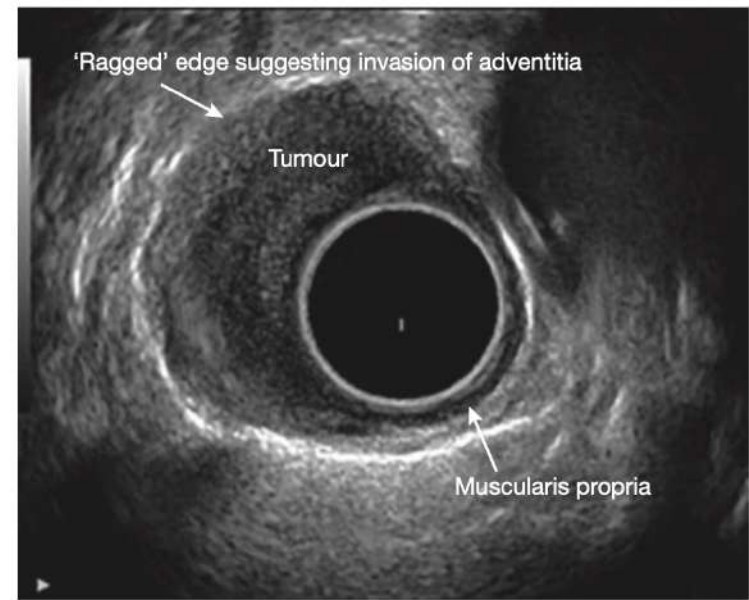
Endoscopic ultrasound image of an oesophageal tumour invading into the wall.
